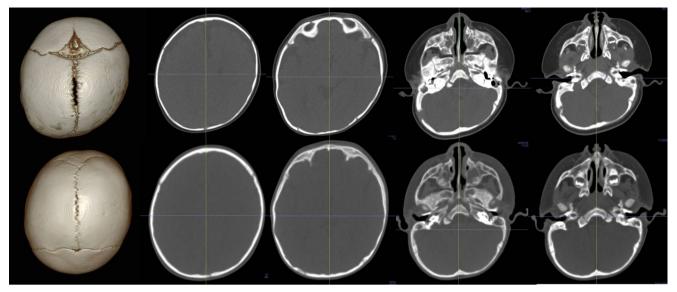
Computed tomography images of a 4-month-old male infant with left-sided plagiocephaly. *Upper row* before treatment; *lower row* after treatment. From *left* to *right*: 3D CT image above vertex, upper cranial level, lower cranial level, midface level, and ear tragus level. 3D CT image was flipped as a mirror image to make it easy for understanding. Left occipital flattening, frontal bossing, and anterior displacement of left ear were noted before treatment. Significant improvement was achieved
